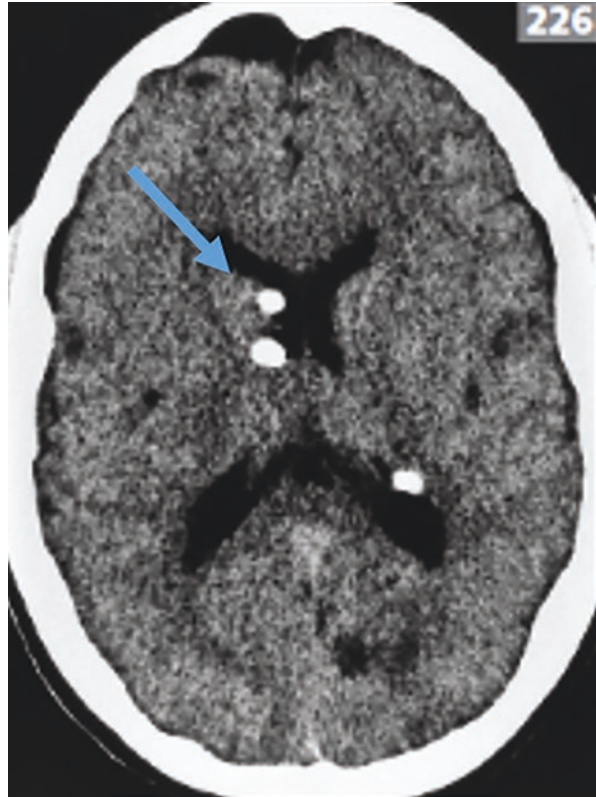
A CT non-contrast scan of the brain, showing bright, calcified subependymal nodules bilaterally on the ventricular surface in tuberous sclerosis
